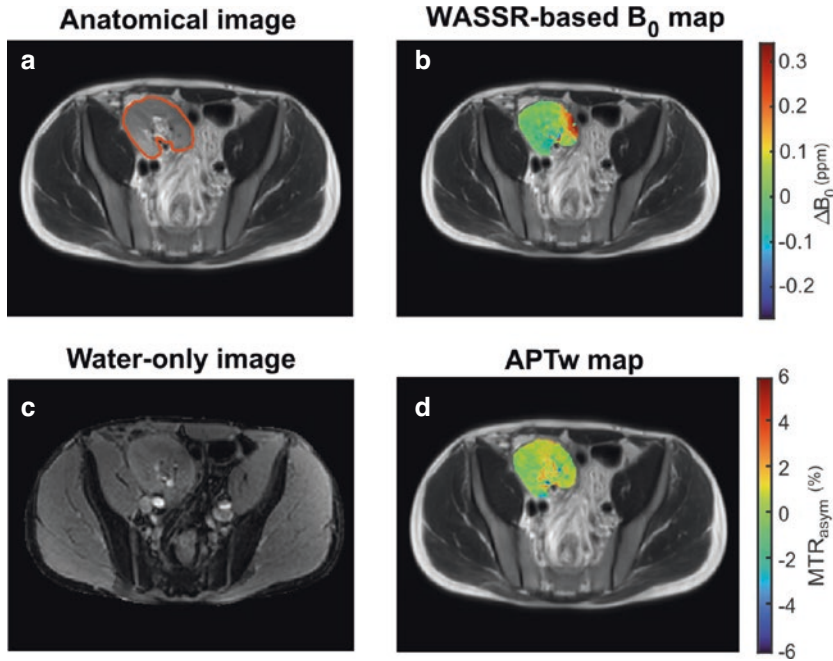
Exemplary T2-weighted anatomical image of the lower abdomen with a segmented kidney, a B_0 map generated using the water saturation shift referencing (WASSR) approach, a water-only image obtained using the 2-pt Dixon water-fat decomposition method, and the corresponding amide proton transfer-weighted (APTw) map. (a) The renal transplant placed in the right iliac fossa
